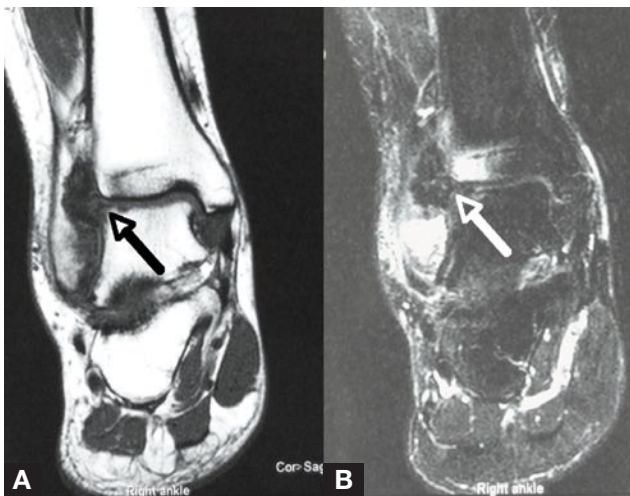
T₁-weighted (A) and T₂-weighted (B) magnetic resonance imaging of right ankle shows large multinodular mass in posterolateral aspect of ankle.
